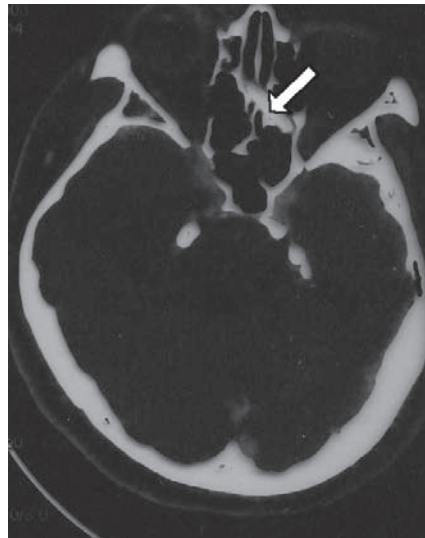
The foreign body is shown (arrow) on coronal CT extending from the floor of the right orbit to the apex of the left orbit. The ethmoidal sinuses were clear.
